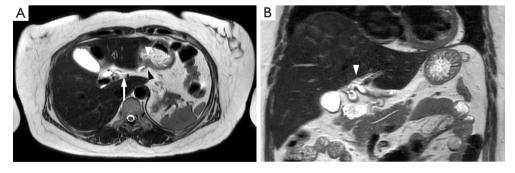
Magnetic resonance imaging of accessory left bile duct draining into the stomach. (A) Axial T2-weighted image of magnetic resonance imaging demonstrated a tubular cystic lesion (white arrow). A gastric pseudotumoral lesion or wall thickening (white arrowhead) was observed at the opening (black arrowhead) into the lesser curvature side of the stomach. (B) On coronal T2-weighted image of magnetic resonance imaging, a tubular cystic lesion was arising from the left hepatic duct (white arrowhead).
